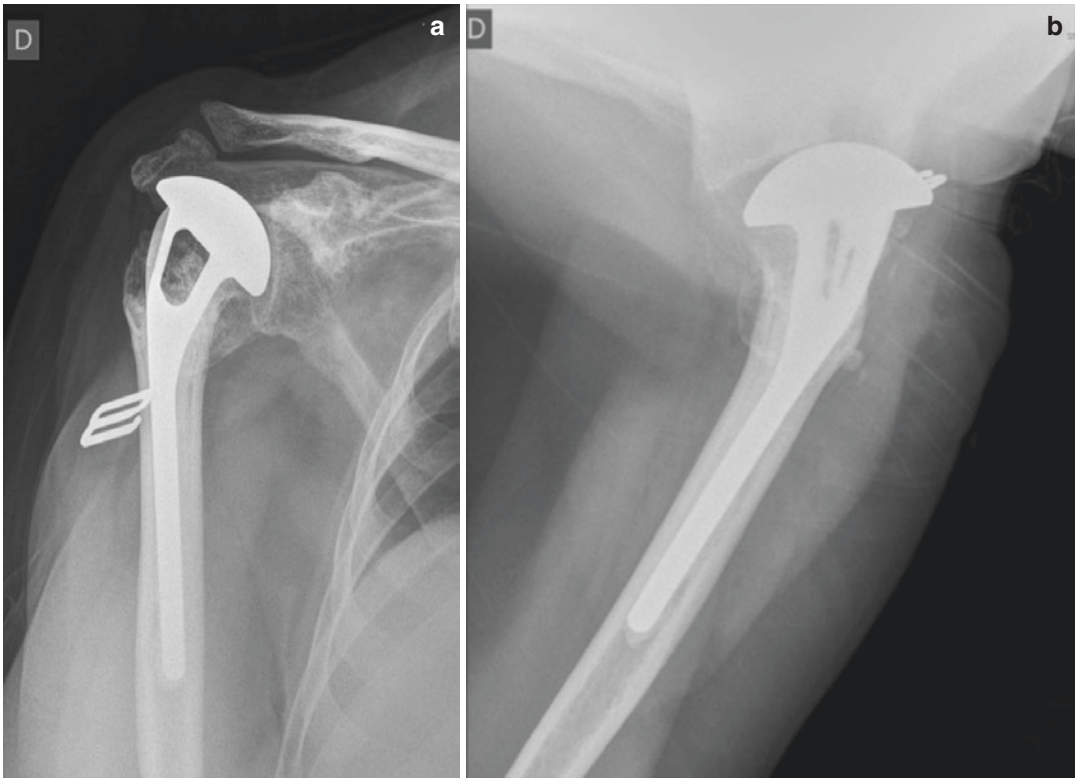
Anteroposterior (a) and axillary (b) radiographic views of shoulder HA. Images reveal superior migration of the prosthesis, reduced acromio-humeral distance, and partial resorption of the greater tuberosity
